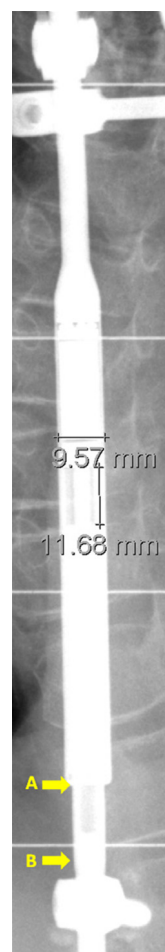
Radiographic measurement of rod distraction length in the housing unit of the magnetically controlled growing rod. The distracted length here was measured at 11.7 mm, and the diameter of the housing unit was measured at 9.6 mm. The diameter of the housing unit must be measured on x-rays to calibrate the measurements for magnification error. Because the actual housing unit diameter was 9.02 mm, the actual distracted length here was calculated to be 11.0 mm. In this figure, Points A and B indicate the corresponding reference points used for ultrasound measurements in Fig. 1.
